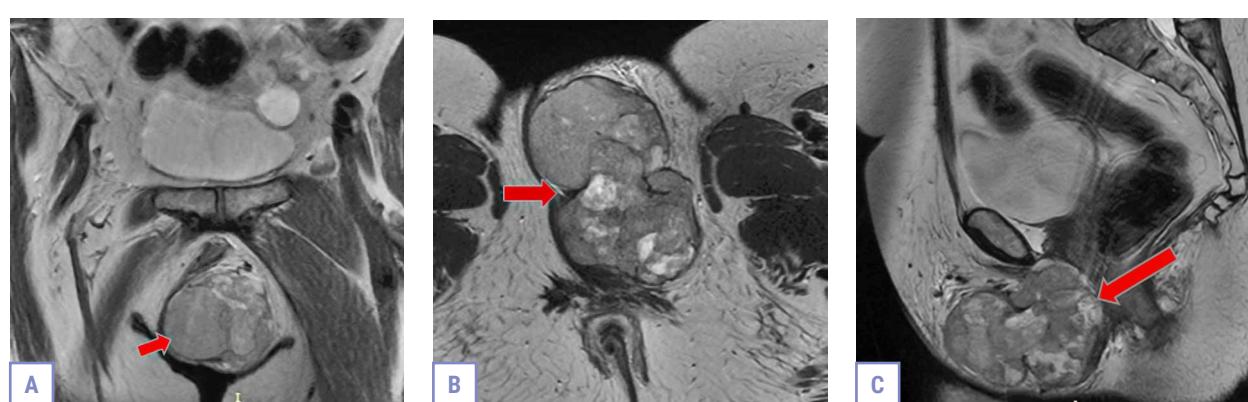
MRI of the pelvic organs with intravenous contrast enhancement in three projections (A, B, C): a multinodular lesion of heterogeneous structure was detected in the left labium majus (indicated by arrows), measuring up to $55 \times 78 \times 99$ mm, adjacent to the left puborectal muscle and the distal part of the urethra without signs of its invasion.
